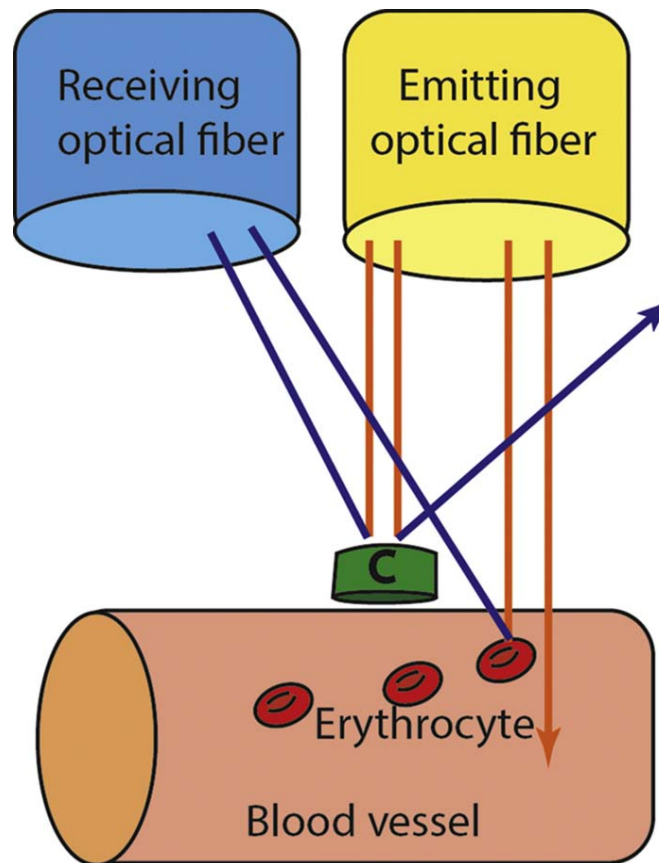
shows the effect of doppler applied to laser radiation. C displays an immobile cell (Kouadio et al., 2018).
